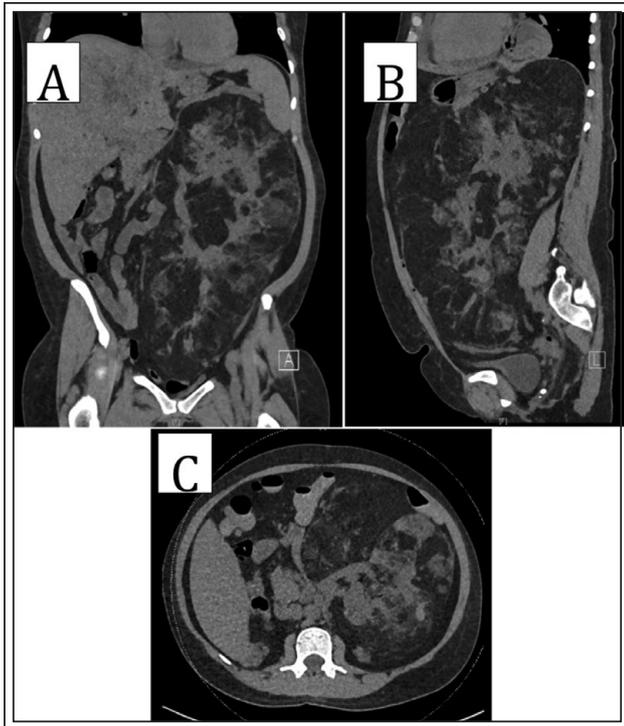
CT images in coronal (panel A), sagittal (panel B), and transverse (panel C) planes demonstrating a large left renal mass.
